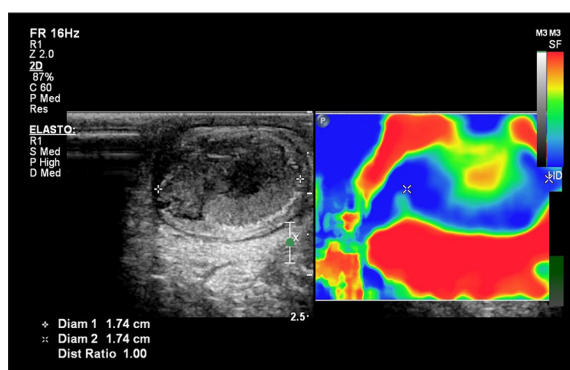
A One-day-old newborn with suspected prenatal testicular torsion. Ultrasonography revealed enlarged and heterogenous right testicle. Elastography revealed abnormal structure of the right testicle – stiffer peripheral part with soft-tissue central part (hard tissues are displayed in blue, soft tissues – in red).
